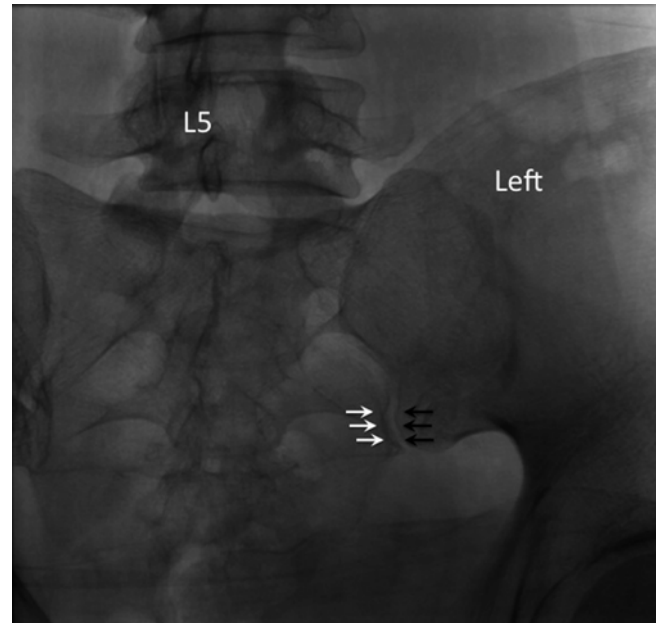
Contralateral oblique X-ray of the sacroiliac joint. The anterior and posterior joint lines aligned to form a crisp silhouette of the joint (Reproduced with permission of Philip Peng Educational Series)
